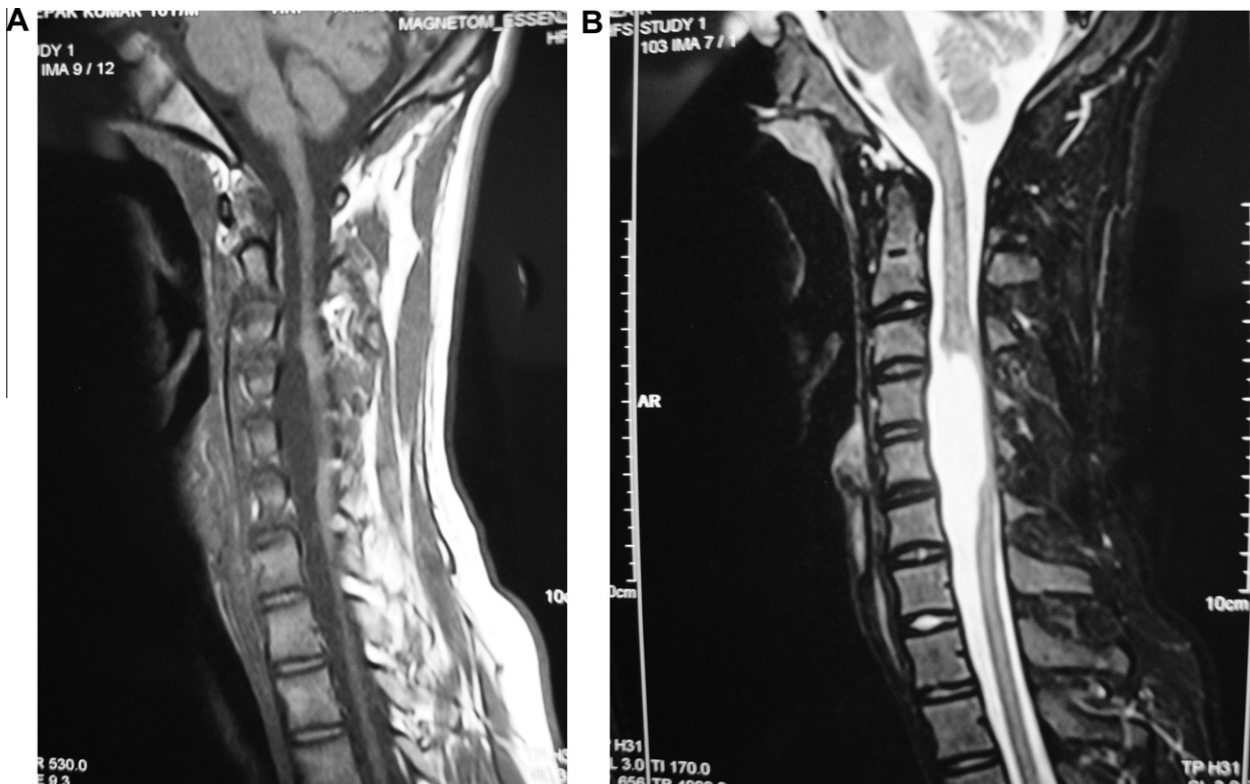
Sagittal cervical (A) T1-weighted and (B) T2-weighted MRI showing an anteriorly placed arachnoid cyst.
